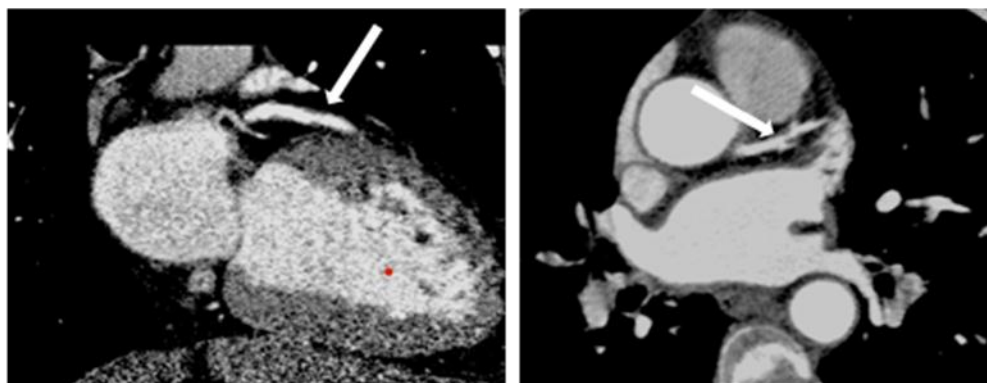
A 54-year-old symptomatic woman. Curved planar reformatted (Left) and axial (Right) CT angiography images show a noncalcified soft plaque (white arrows), which is causing a significant (60%) stenosis in the LAD
